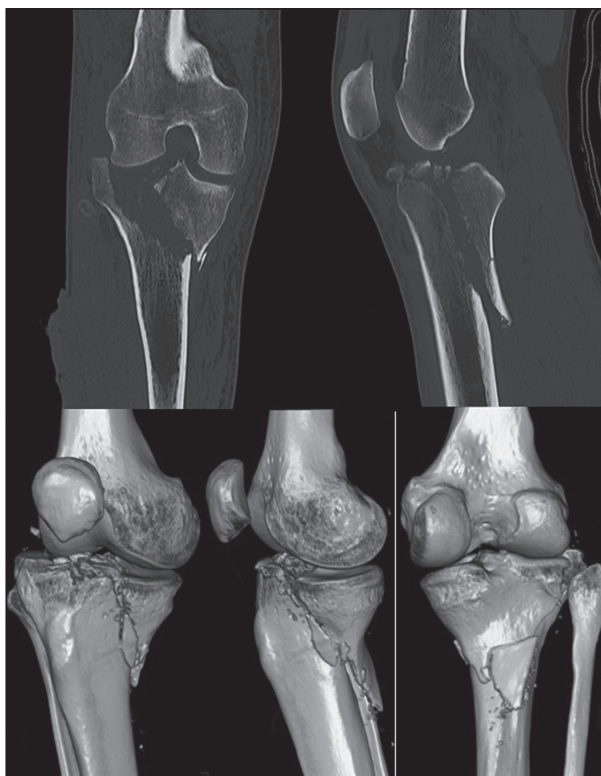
CT scans with 3D reconstruction.
